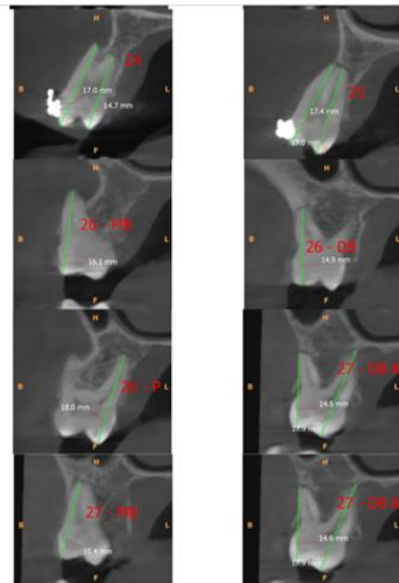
Post treatment CBCT for root length measured along long axis of tooth in sagittal section
